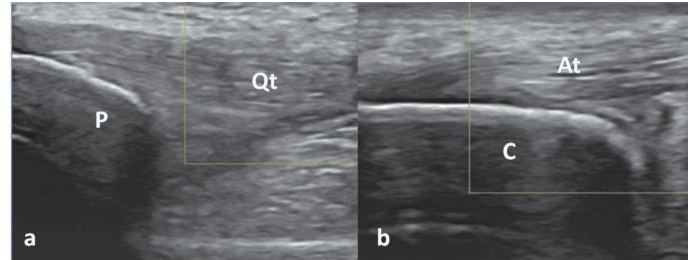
A repeat imaging (4 weeks after treatment) reveals the disappearance of the effusions and the power Doppler signal at knee (a) and ankle (b). P, patella; C, calcaneus; Qt, quadriceps tendon; At, Achilles tendon
